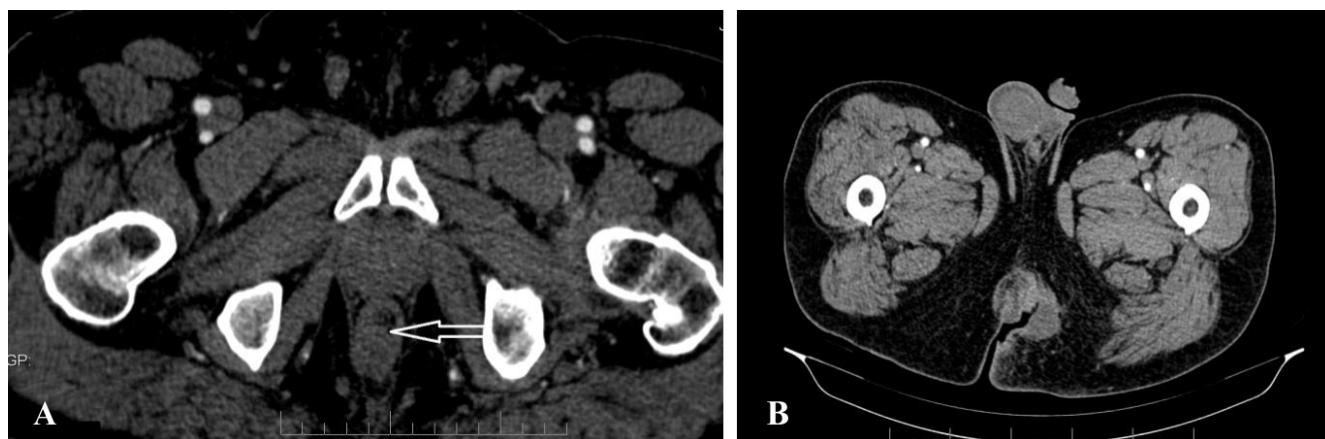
Abdominal-pelvic CT scan performed following fistulectomy: a) thickening of the posterior rectal wall – initially interpreted as inflammatory; b) fluid perianal collection with cutaneous communication (corresponding to the post resection wound following excision of the fistulous tract).
